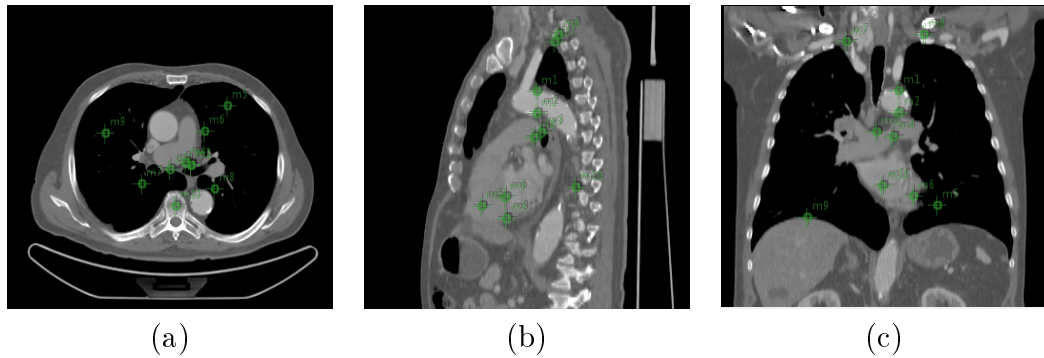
A diagnostic CT image showing distribution of the ten anatomical reference landmarks.
